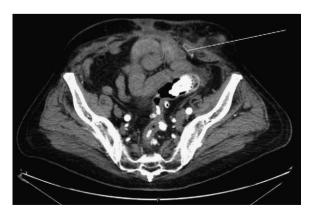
Venous phase axial abdominal computed tomography (CT) scan demonstrating the left lateral wall swelling (arrow).
